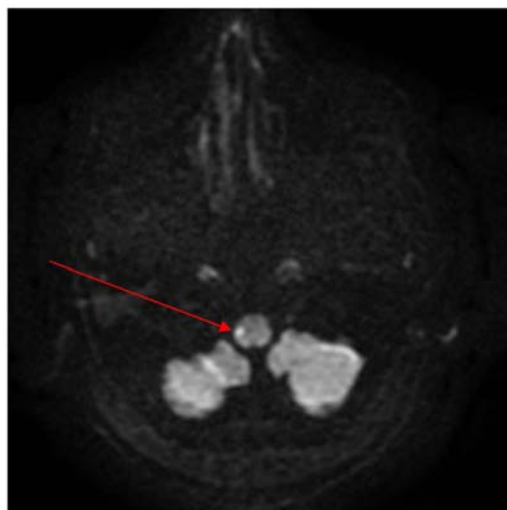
Showing diffusion MRI sequence with lateral medullary acute ischemia. The hyper intense signal in the lateral medulla is indicated by the red arrow.
